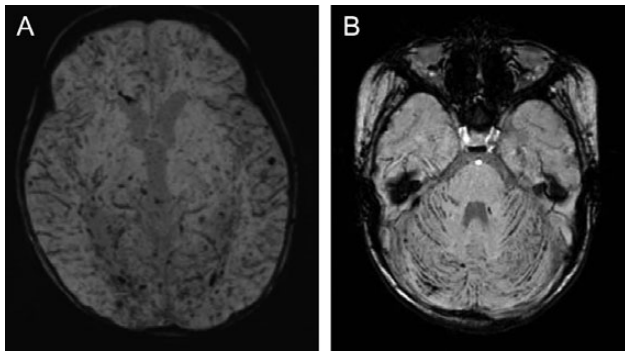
Brain magnetic resonance imaging (susceptibility-weighted imaging sequence) for 2 children with *Angiostrongylus* meningoenkephalitis, on day 23 of admission for case 1 (A) and on day 18 of admission for case 2 (B).
